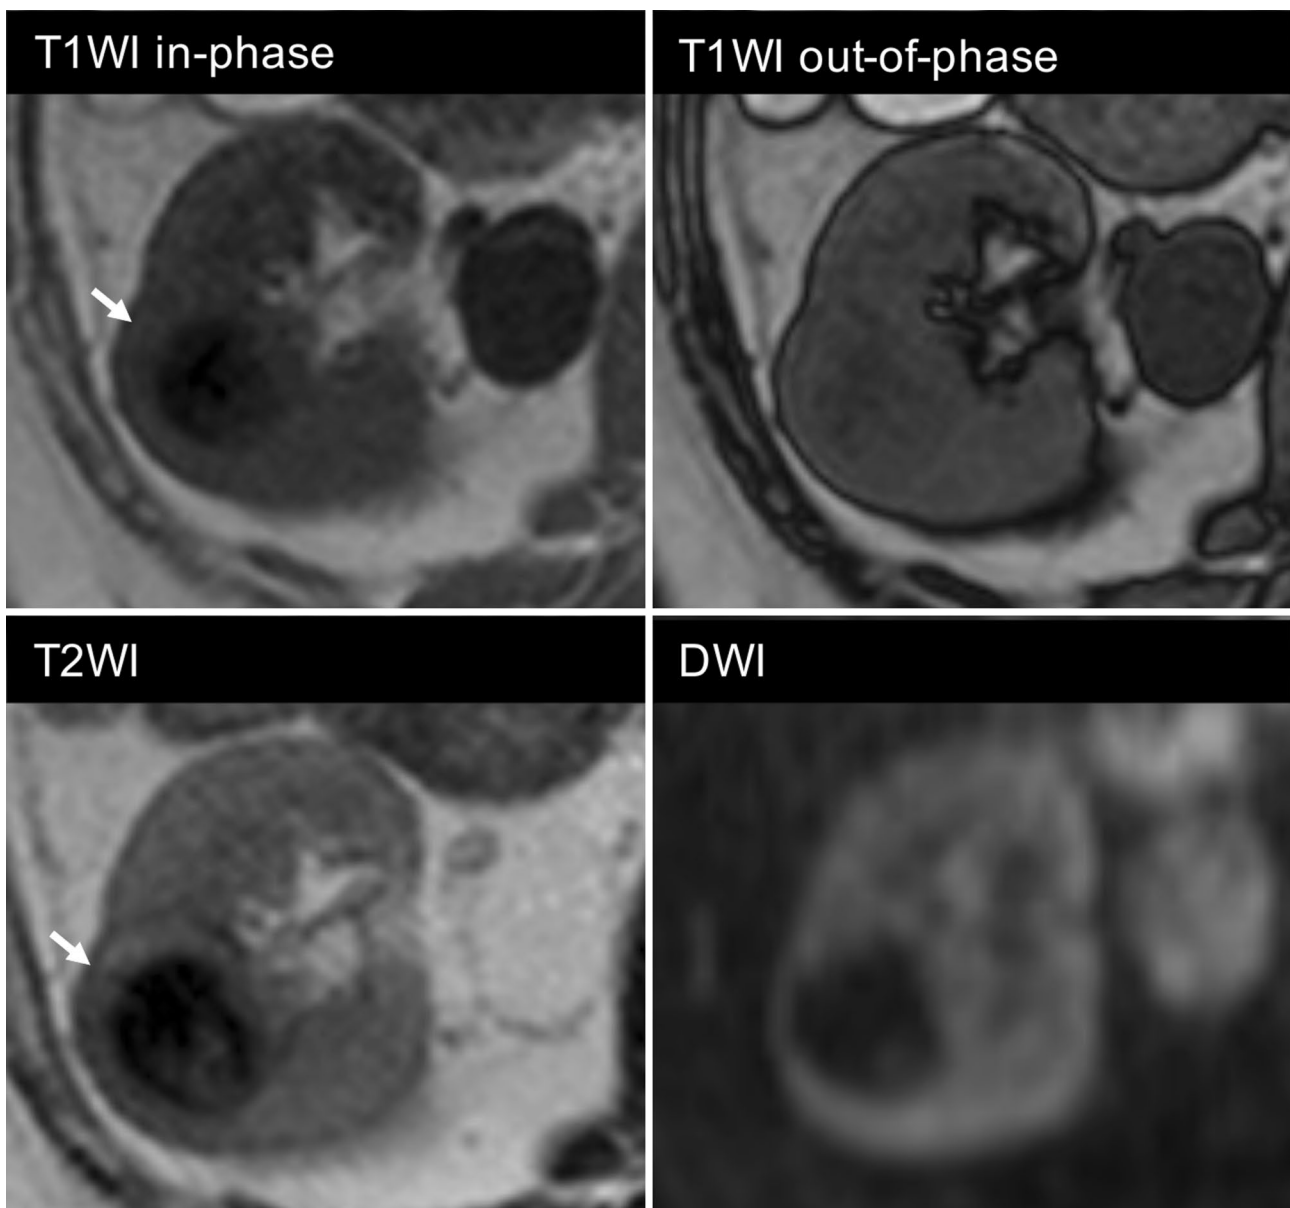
On MRI, the mass shows hypointensity on both T1WI and T2WI. The signal from in-phase images is decreased. DWI (b value=1000) also shows decreased intensity. The rim of the mass shows almost equal intensity with renal parenchyma on T1WI and T2WI (arrows)
